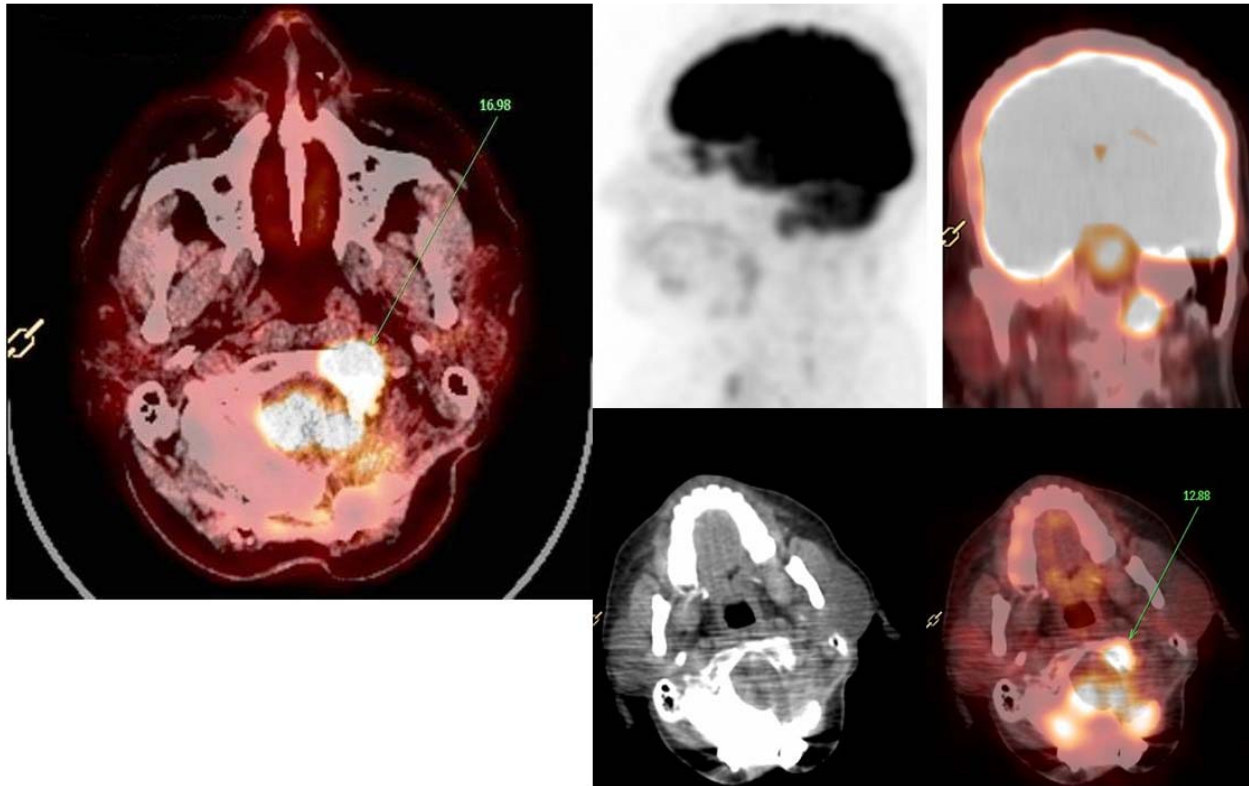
FDG-PET/CT (Pre- and Post- 1st cycle of ^{177}Lu -DOTATATE PRRT) at 3 months showing reduction of tracer uptake from 16.98 to 12.88 i.e. reduction of 24.15%.
